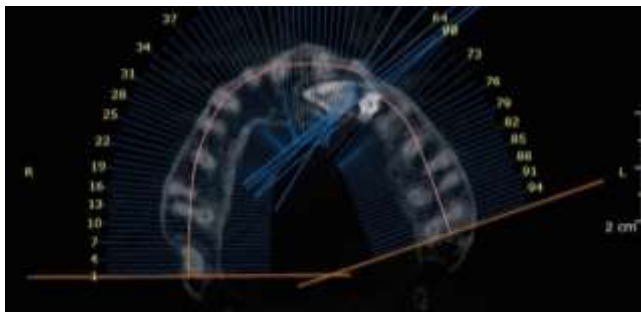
CBCT radiographic examination after 4-years follow-up. No abnormal reaction was seen.
